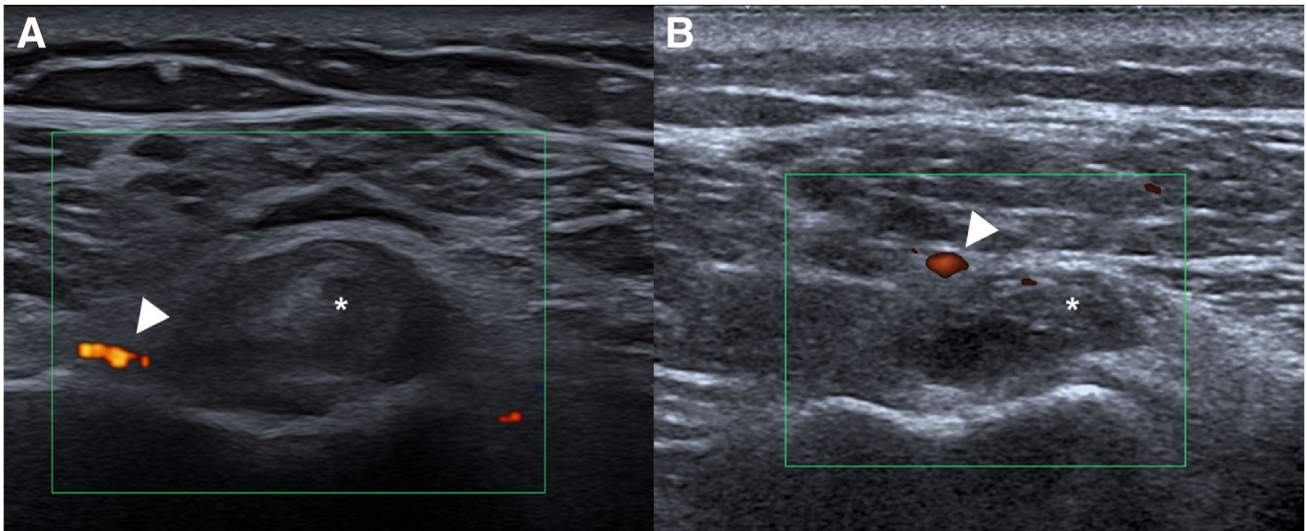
Doppler imaging is used to identify any vessels, with transverse ultrasound scanning over the biceps tendon (*) with Power Doppler in 2 different patients, demonstrating that tendon sheath vessels (arrowheads) may not always be located in the same anatomical position. The patient assumes a supine position with the right shoulder exposed, followed by the implementation of aseptic measures. The view is an axial transverse view, lateral to medial.
